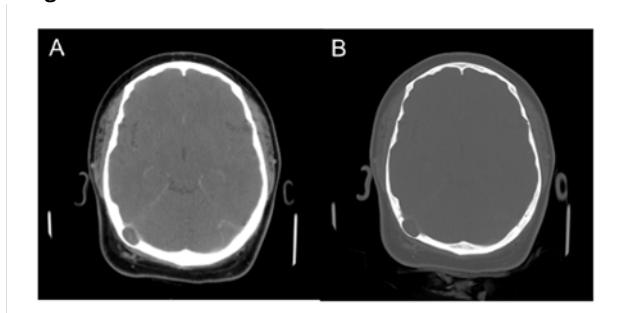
Soft tissue (A) and bone (B) algorithm axial slice contrast enhanced CT head demonstrates a 1.8 cm intradiploic lucent lesion within right occipital calvarium which markedly thins the inner table (B) and exerts mass effect upon the transverse sinus (A).
